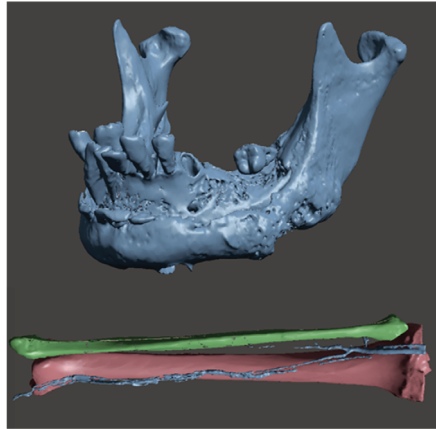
CT data acquisition of the mandible and fibula.
